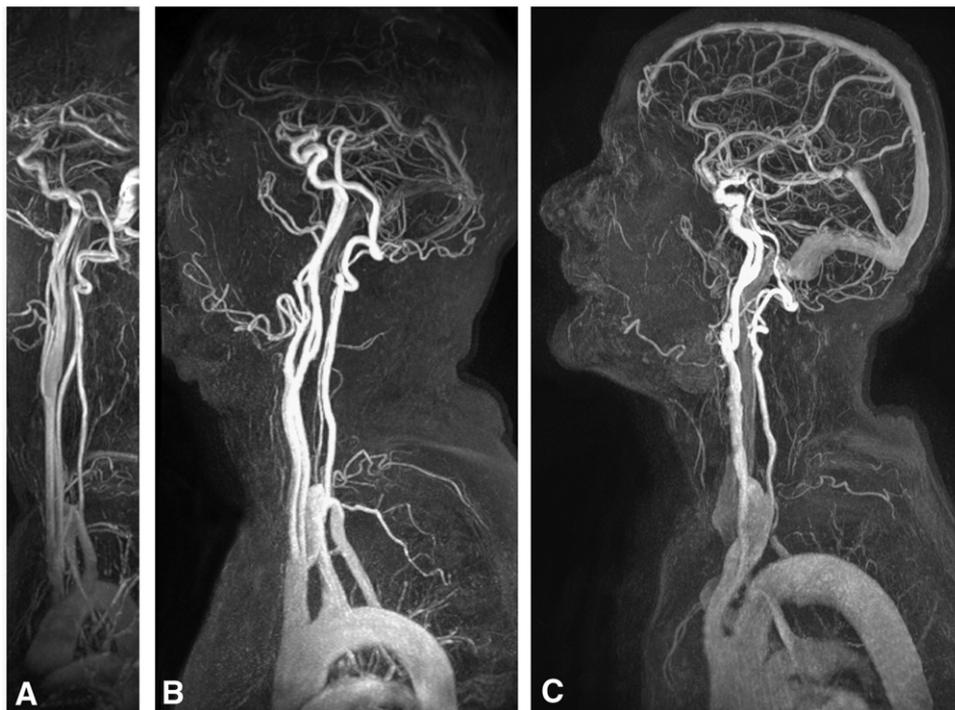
(A) Supraaortic MRA images of a 30-year-old female healthy volunteer: sagittal maximum intensity projection from T1-weighted GRE sequence (5.1/1.5/30°) using a parallel imaging factor of 1 (without undersampling). The acquired spatial resolution was $0.81 \times 0.81 \times 1.0 \text{ mm}^3$. (B) Supraaortic MRA images of a 63-year old male patient: sagittal maximum intensity projection from T1-weighted GRE sequence (5.1/1.9/30°) with a parallel imaging factor of 4. The acquired spatial resolution was $0.68 \times 0.68 \times 0.98 \text{ mm}^3$. Note the visualization of the peripheral segments of the intracranial arteries as well as of the facial and suprascapular arteries which is caused by the extended anatomic coverage. (C) Supraaortic MRA images of a 75-year-old female patient with a minor stenosis (<50%) of the left internal carotid artery: sagittal maximum intensity projection from T1-weighted GRE sequence (4.9/1.9/25°) using a parallel imaging factor of 16. The acquired spatial resolution was $0.46 \times 0.46 \times 0.98 \text{ mm}^3$. Venous enhancement does not interfere with image interpretation.
